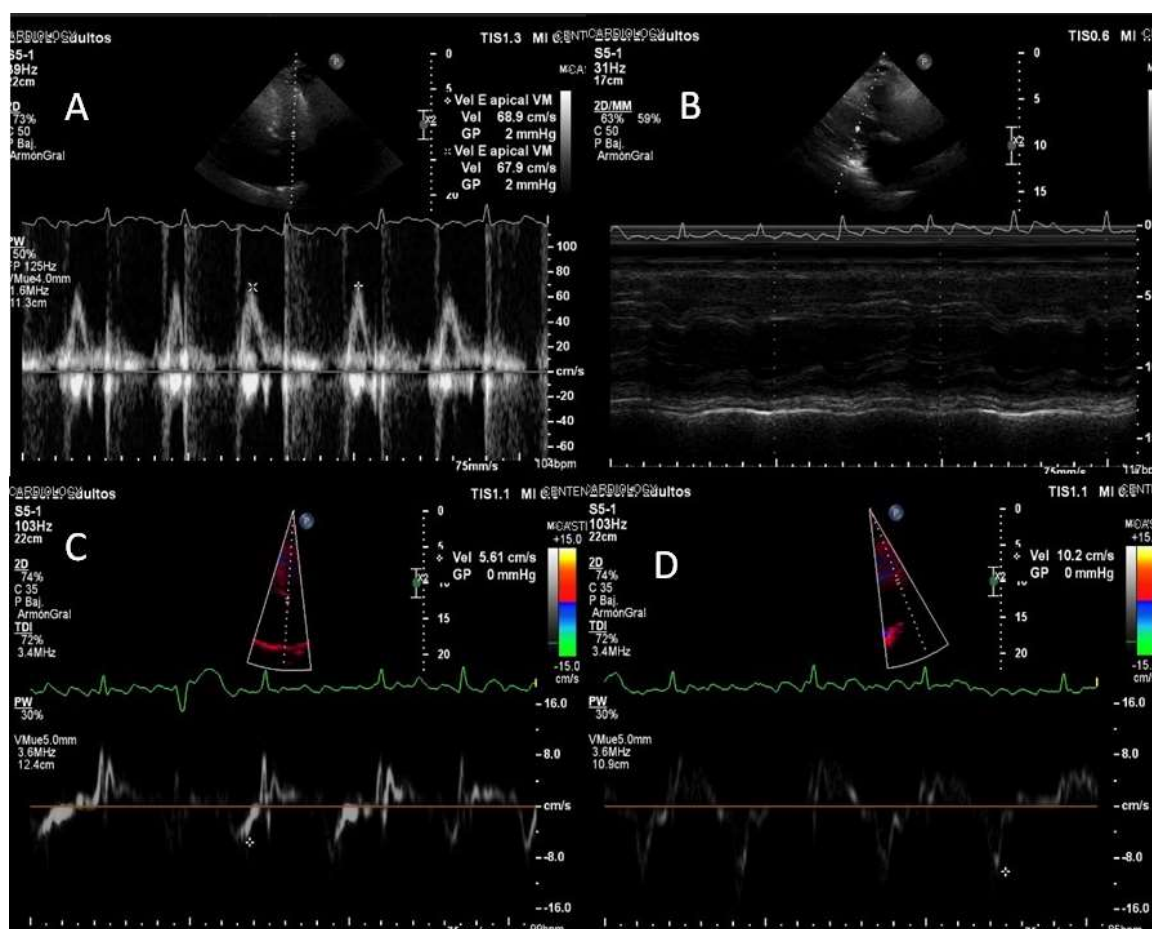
Transmitral Doppler without variation with respiration (A), M-mode normal septal motion (B), tissue Doppler of the medial and lateral annulus without reverse annulus (C and D)
